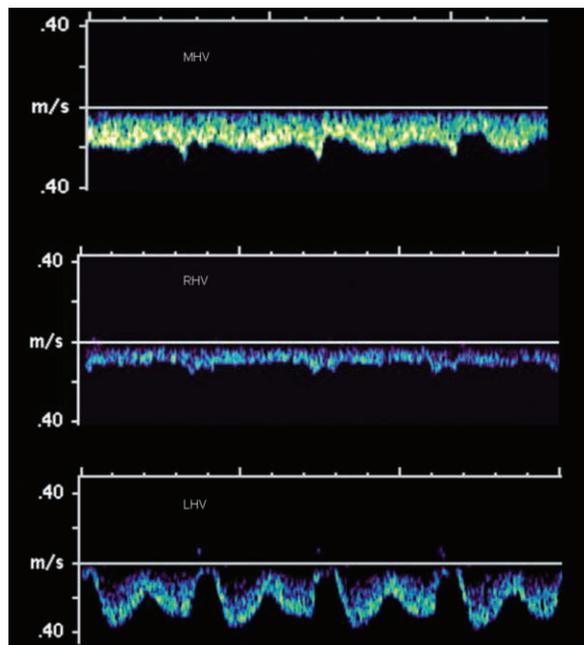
Different waveforms in the three hepatic veins of a patient with no medical history. Doppler spectra show a near-monophasic waveform in the right hepatic vein (middle), a blunted waveform in the middle hepatic vein (top), and a normal waveform in the left hepatic vein (bottom). The patient had no underlying liver disease; we believe that the presence of different patterns was due to technical factors.
